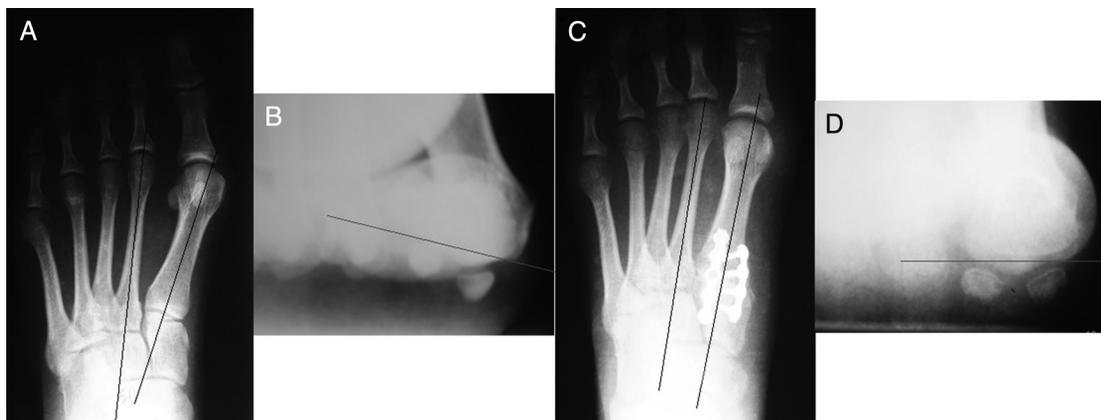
(A) The transverse plane deviation of the metatarsal observed on an anteroposterior radiograph. (B) The frontal plane rotation of the metatarsal observed on a sesamoid axial radiograph. Both adduction of the metatarsal and the valgus (pronated) frontal plane rotation are anatomic components of a bunion. (C and D) Correction of the transverse plane and frontal plane aspect of the deformity, with resultant realignment of the sesamoids, without soft tissue balancing.
